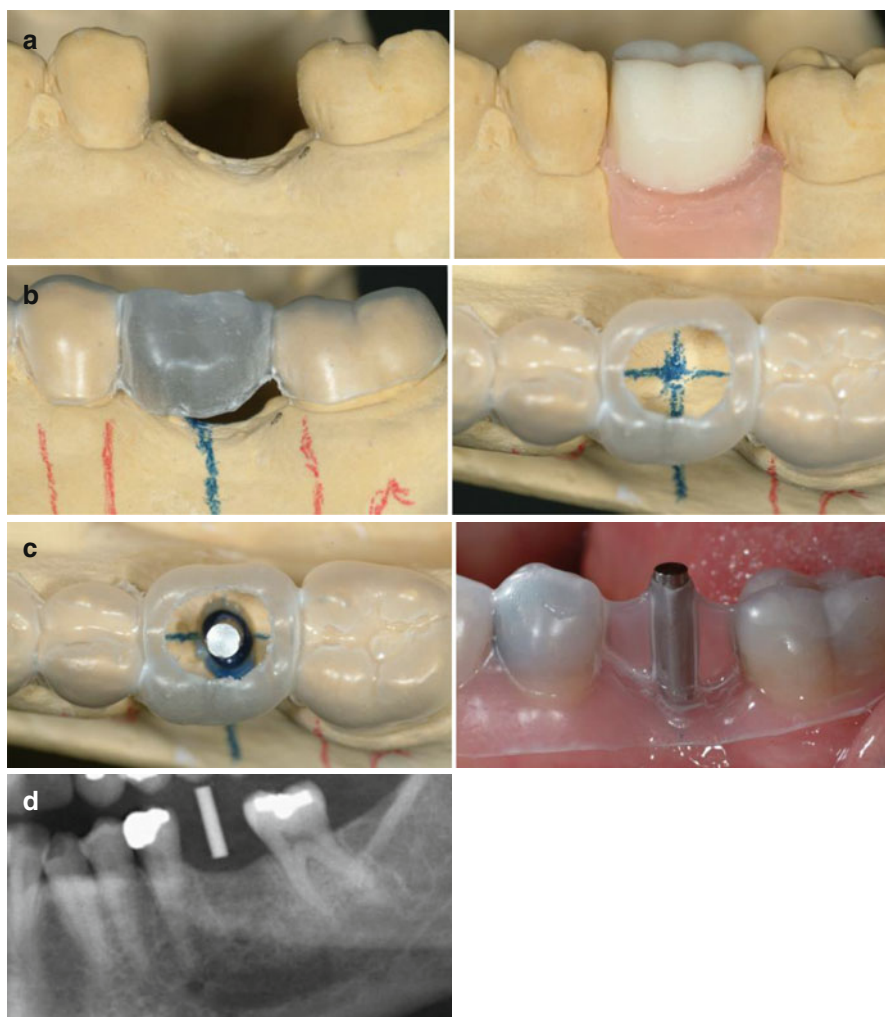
(a) When using in-office guides, a wax-up can be done using denture teeth and triad material to stabilize the tooth at the correct tridimensional position, including correct occlusion and proposed gingival margin. A guide can be fabricated using the method published by Higginbottom and Wilson in 1996. (b) A vacuum-formed material (copyplast 1 mm) is used to create a template over the “wax-up.” Lines are drawn in the cast following the adjacent root position according to the examination/initial radiography. (c) At this point, using a 2-mm-diameter twist drill and following the correct position, a “cast surgery” can be done, and perforation on the cast is created. A 2-mm-diameter rod is adapted to the cast and a new vacuum-formed template is done to create a radiographic guide. (d) The radiographic evaluation will allow the clinician to plan the best angulation of the implant to respect the adjacent roots and to plan the correct implant length to avoid the anatomic structures. (e) Now a sleeve guide can be fabricated to restrict the mesial/distal and buccal/lingual osteotomy, and the initial full-contour wax-up vacuum form can be used to determine the correct implant depth (vertical guide) according to the implant design. (i.e., tissue level or bone level)
